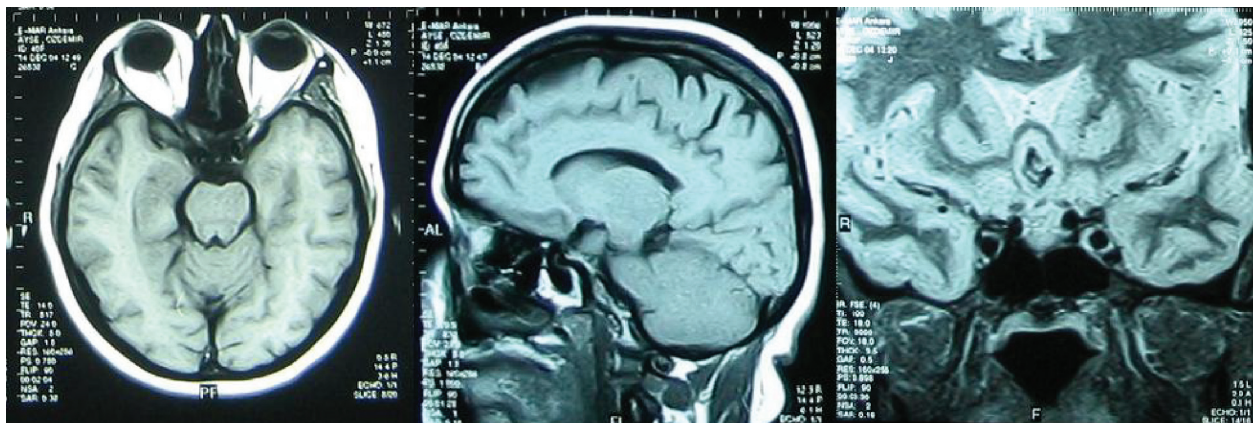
MRI of patient is within normal limits (Axial section—Sagittal section—Coronal section).
